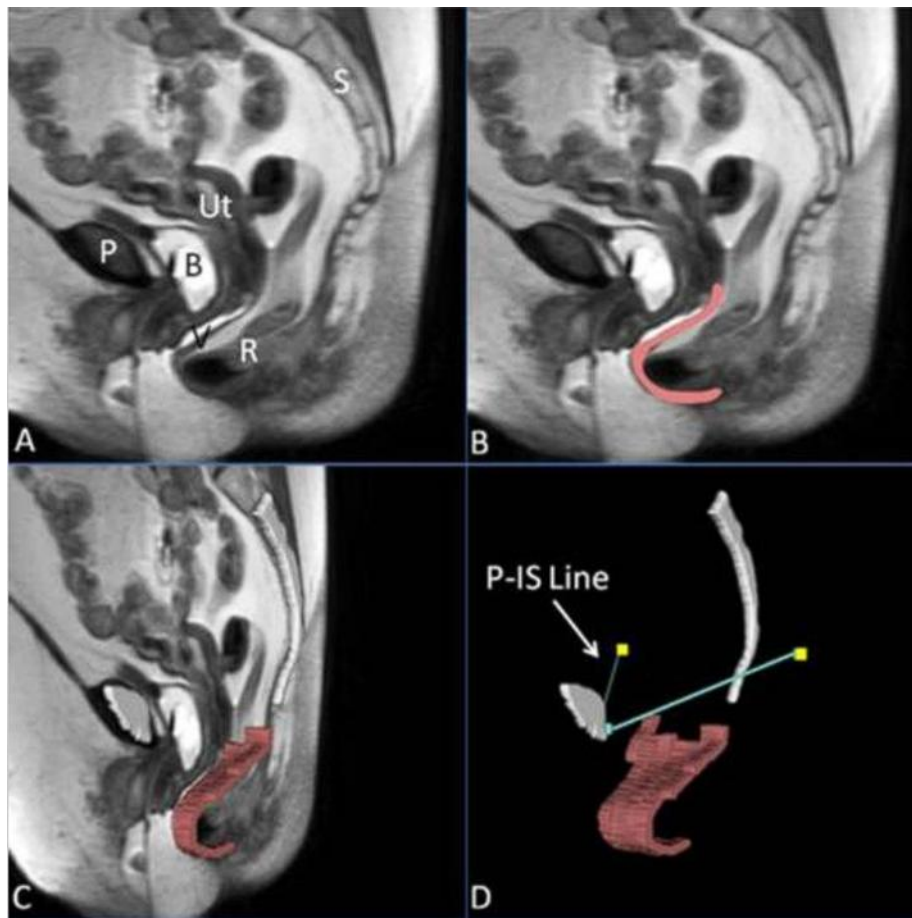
A. Median sagittal MRI scan of a patient with posterior prolapse.
